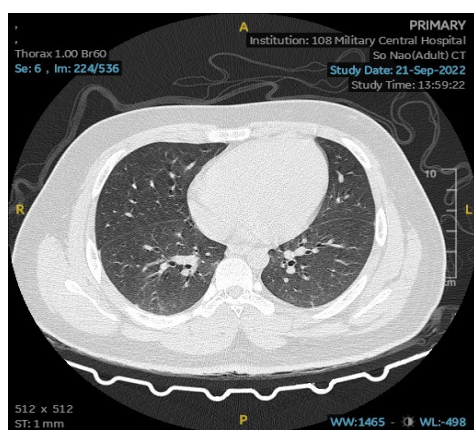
Chest computed tomography on 7th of admission, showed that two clean lungs
